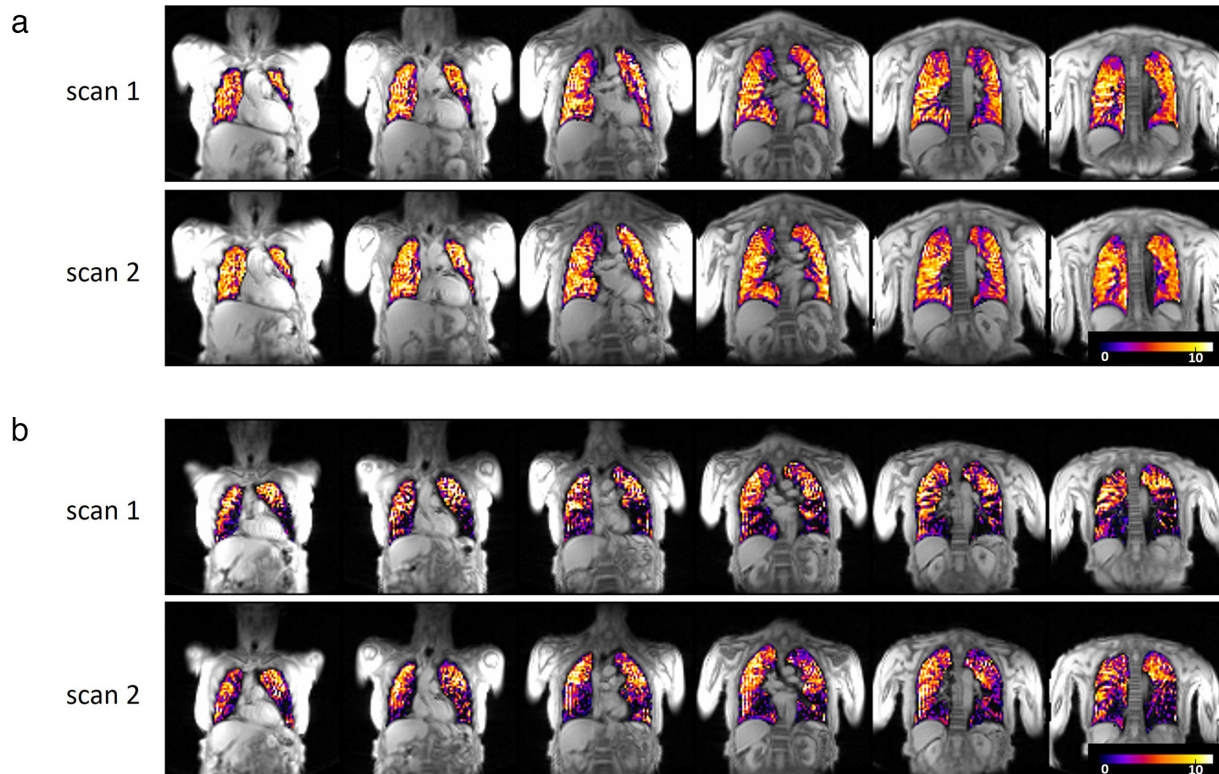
T_2^* -OE-MRI percent signal intensity (PSE (magnitude)) maps for two female participants, age range 60–80 years: healthy subject (A) and patient with COPD (B). Compared with the healthy subject, the patient with COPD maps exhibit more patchy enhancement with ventilation defects in the lower lobes of both lungs. COPD, chronic obstructive pulmonary disease; PSE (magnitude), the magnitude of the percentage difference between mean signal intensity at normoxia and hyperoxia; T_2^* -OE-MRI, T_2^* -weighted oxygen-enhanced MRI.
